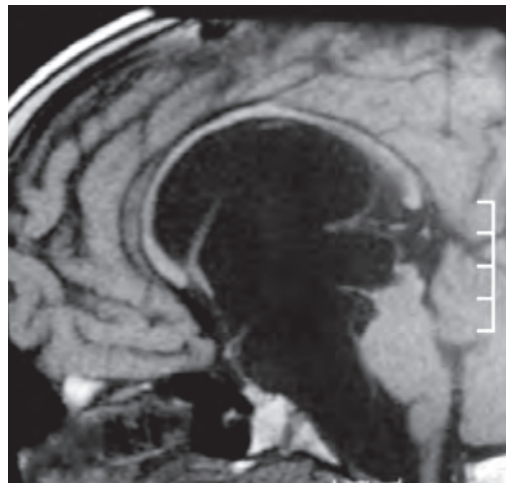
MRI of the brain sagittal T1W image following endoscopic ventriculo cysto cisternostomy
